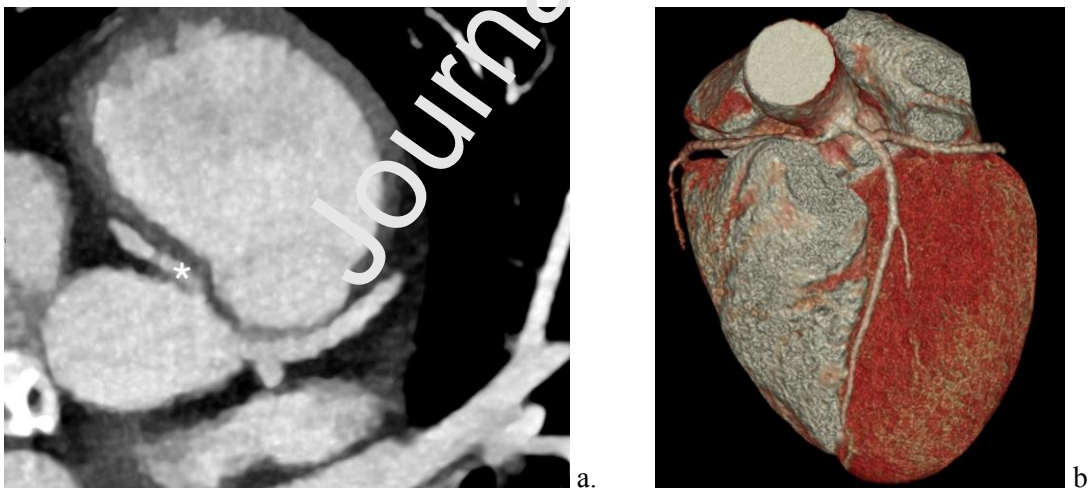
CT scan (a) and 3D-reconstruction (b) of RCA (*) arising from the opposite sinus of Valsalva with interarterial course.
